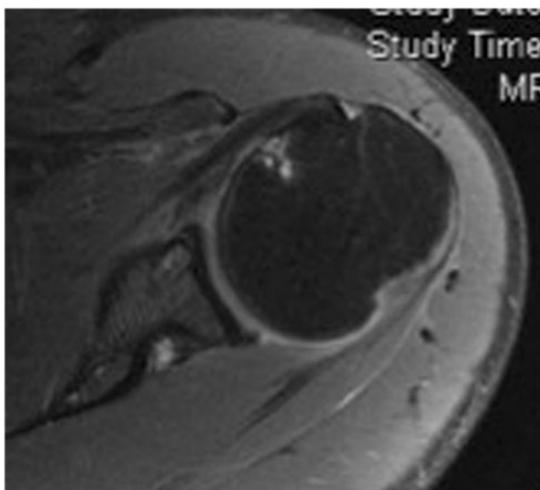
T2-weighted coronal magnetic resonance imaging sequence of the glenohumeral joint showing a moderate sized Hill-Sachs lesion.
